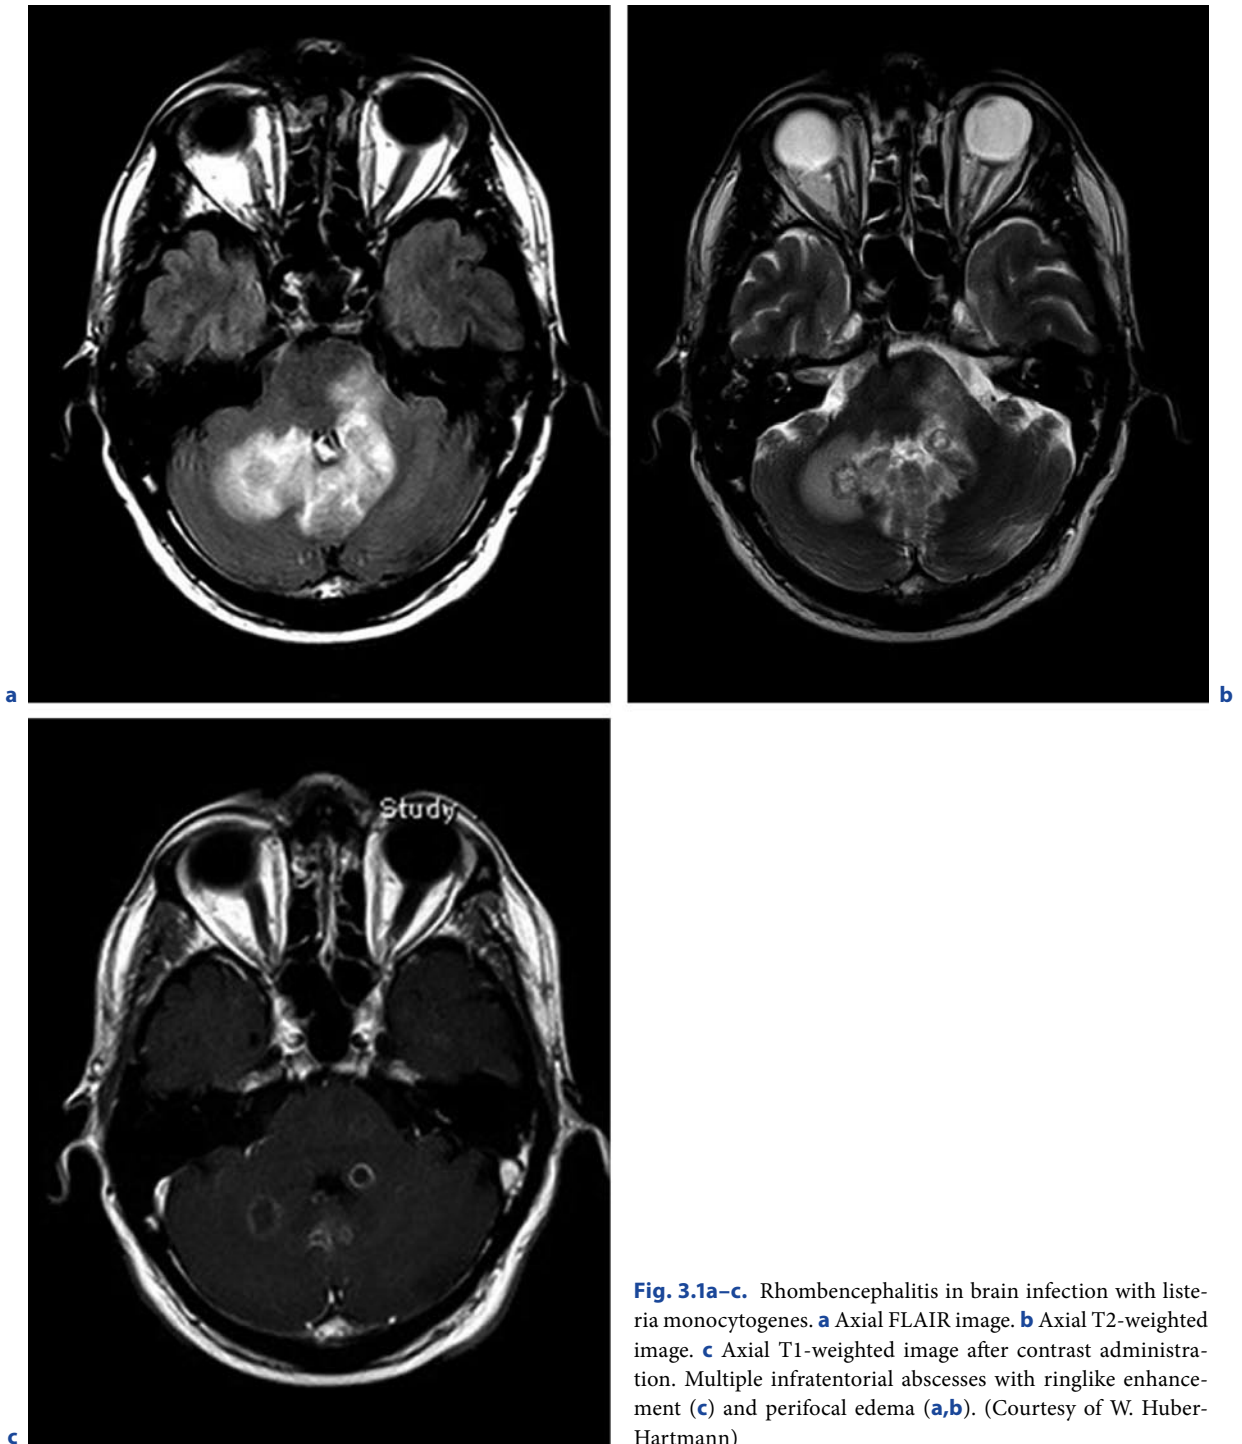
Rhombencephalitis in brain infection with *listeria monocytogenes*. a Axial FLAIR image. b Axial T2-weighted image. c Axial T1-weighted image after contrast administration. Multiple infratentorial abscesses with ringlike enhancement (c) and perifocal edema (a,b). (Courtesy of W. Huber-Hartmann)
